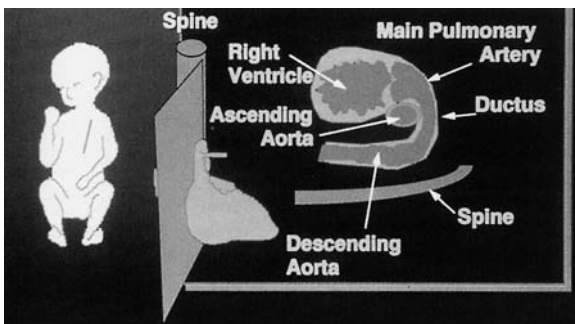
Two-dimensional echocardiogram of the basal short-axis view of the fetal heart. *RVOFT* right ventricular outflow tract, *LA* left atrium, *RA* right atrium, *PA* pulmonary artery, *RV* right ventricle, *da* ductus arteriosus, *rp* right pulmonary artery, *IVC* inferior vena cava
